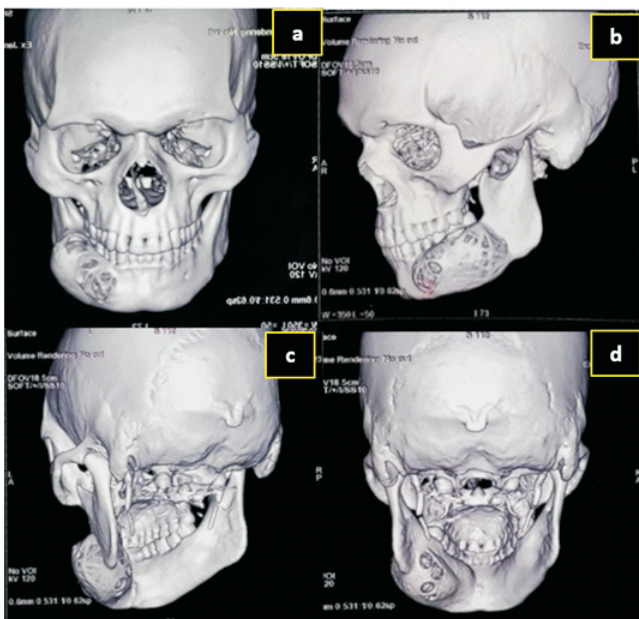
Computed tomography three-dimensional surface shaded display images from frontal (a) and lateral (b) views showing the expansile lesion with smooth outlines without any cortical break.
